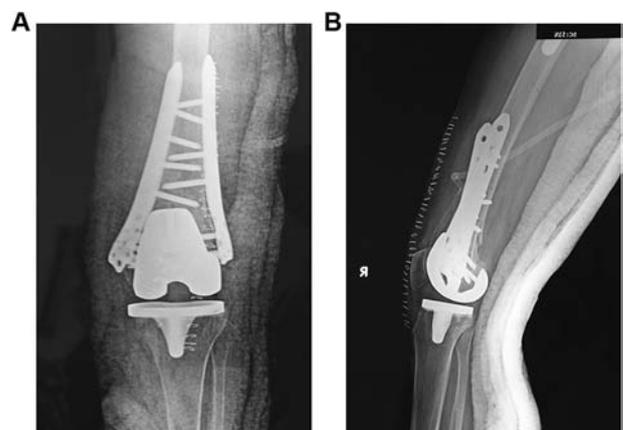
A and B: Postoperative anteroposterior and lateral radiograph showing fracture reduction and osteosynthesis with medial and lateral locking plate.
